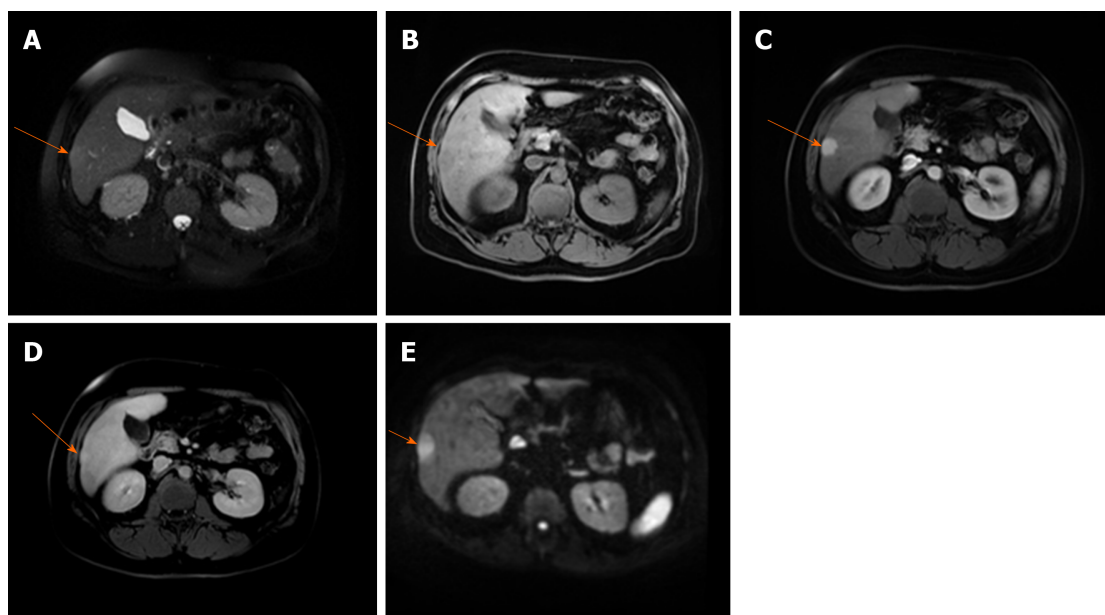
Hepatocellular carcinoma in 64-year old man with cirrhosis. A: Axial T2-weighted FS image shows slightly hyperintense nodular lesion (arrow) located in segment VI; B-D: The lesion is hypointense on T1-weighted fat-saturated image (B), hypervascular on arterial phase (C) without washout on portal-venous phase (D); E: The tumor (arrow) is hyperintense on diffusion weighted imaging.
